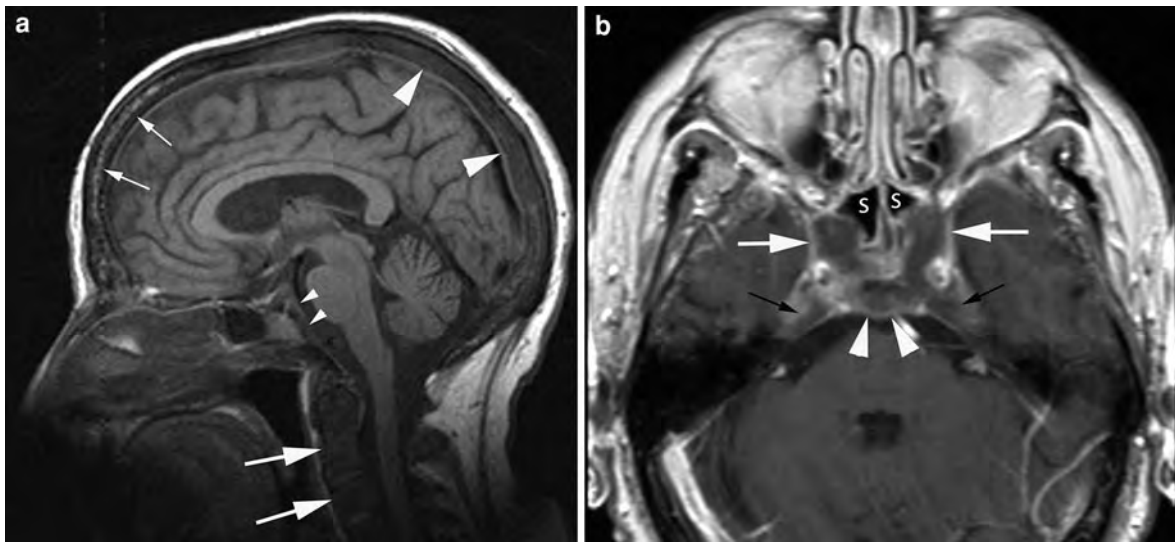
Sagittal, non-contrast enhanced T1-weighted image (a) demonstrates completely replaced fatty bone marrow by diffuse metastatic disease in the majority of the skull (*large arrowheads* in a) and cervical spine (*large arrows* in a) while the bone marrow of the frontal skull is more mottled in appearance (*small arrows* in a) that is consistent with less extensive involvement. In addition, there is lack of fatty bone
